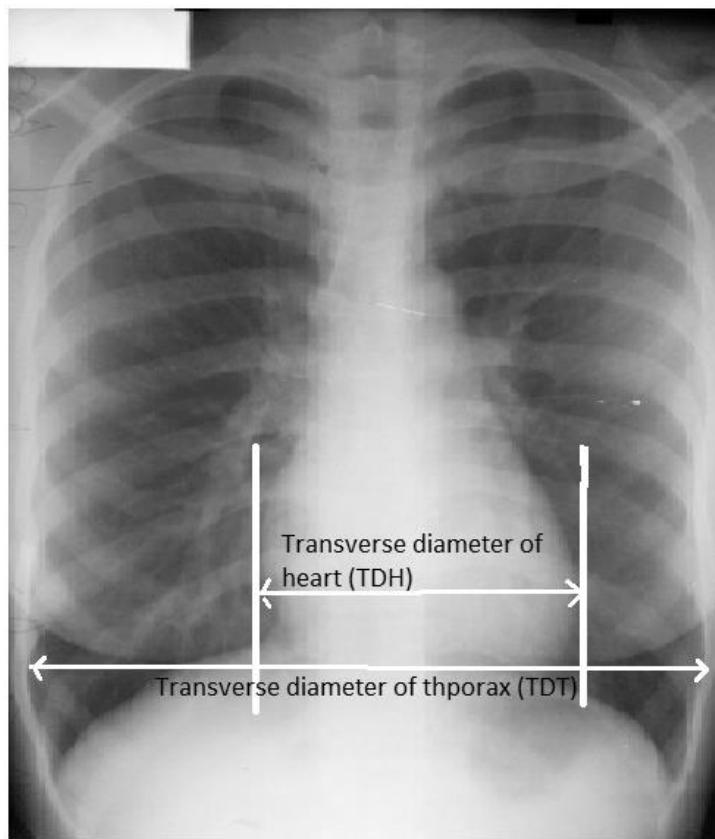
Chest radiograph with lines showing how to measure cardiothoracic ratio.
